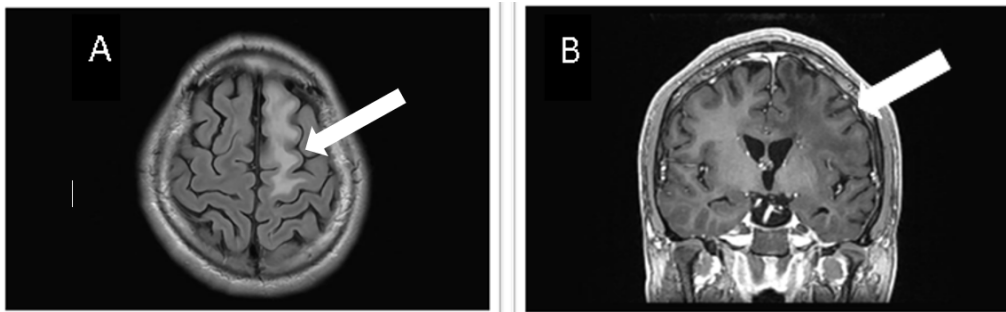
(A). Contrast-enhanced brain magnetic resonance imaging, axial T2 FLAIR sequence. A diffuse hyperintense area is observed in the white matter, with frontoparietotemporo-occipital extension in the left hemisphere and frontal involvement in the right hemisphere. (B). Contrast-enhanced brain magnetic resonance imaging, coronal T1 sequence. The arrow indicates a diffuse hypointense area in the white matter, with frontoparietotemporo-occipital extension in the left hemisphere and frontal involvement in the right hemisphere.
